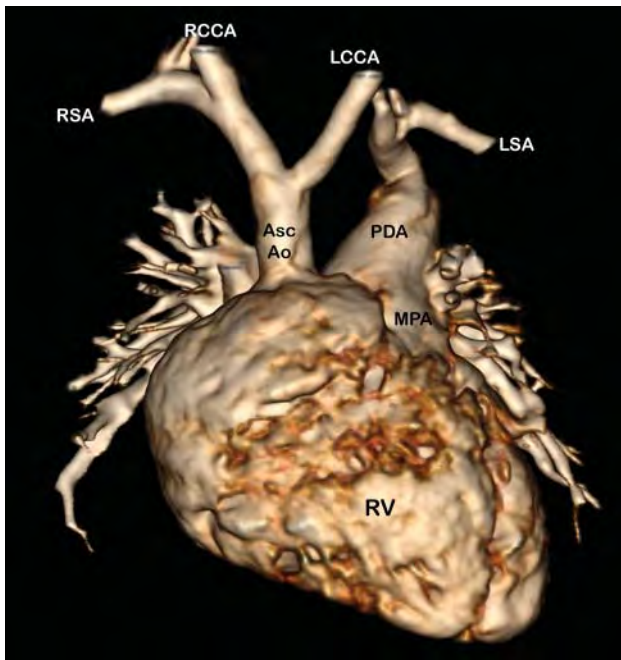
Computed tomographic three-dimensional (3D) reconstruction of type B interrupted aortic arch. RV, right ventricle.
